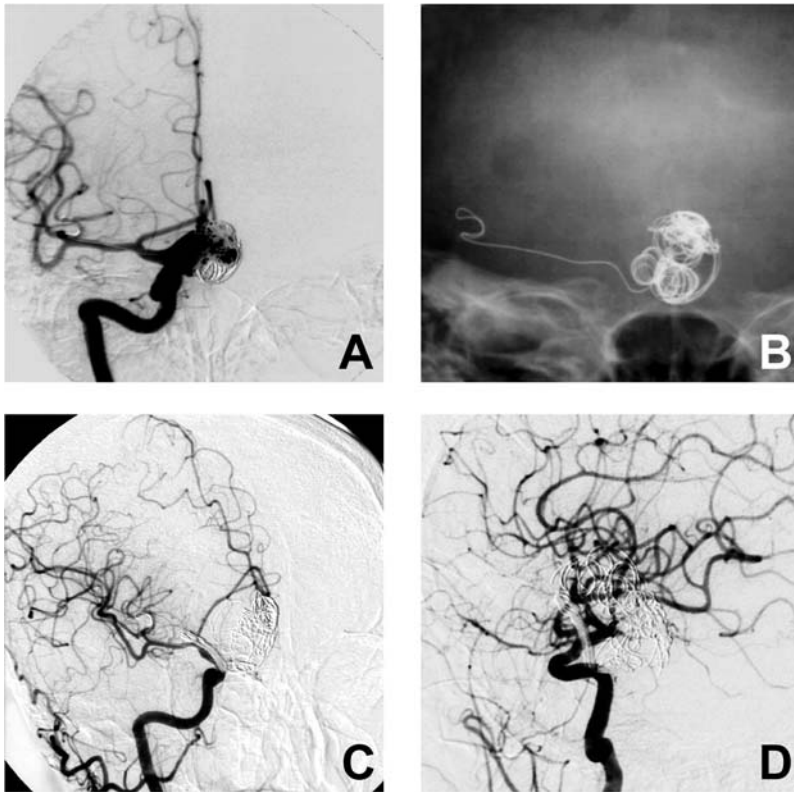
A 66-year-old female. Preoperative right internal carotid angiogram (A) and skull X-ray (B) showing recanalization and regrowth of the aneurysm which was successfully embolized previously with Guglielmi detachable coils. Migration of the coil from the aneurysm lumen to the left M2 segment of the middle cerebral artery (*MCA*) can be seen. Postoperative A-P (C) and lateral (D) carotid angiograms showing complete clipping of the aneurysm, remaining migrated coil in the internal carotid artery to the *MCA*
